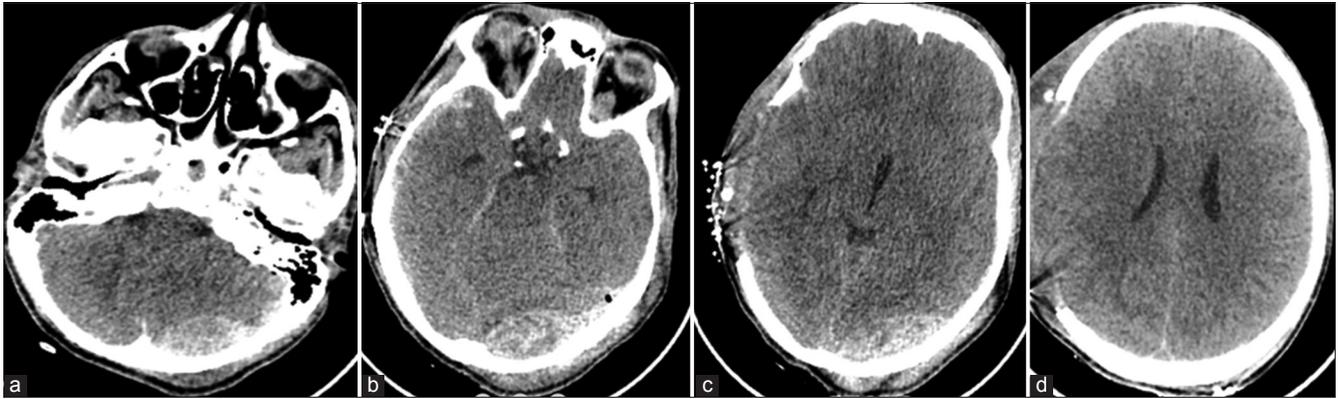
(a-d) Early control post-operative axial plan cranial computed tomography showing evacuation of the subdural hematoma on the right frontoparietotemporal region of the brain and resolution of midline shift, but there is epidural hematoma on the left occipital region of the brain extended into the posterior fossa detected postoperatively
